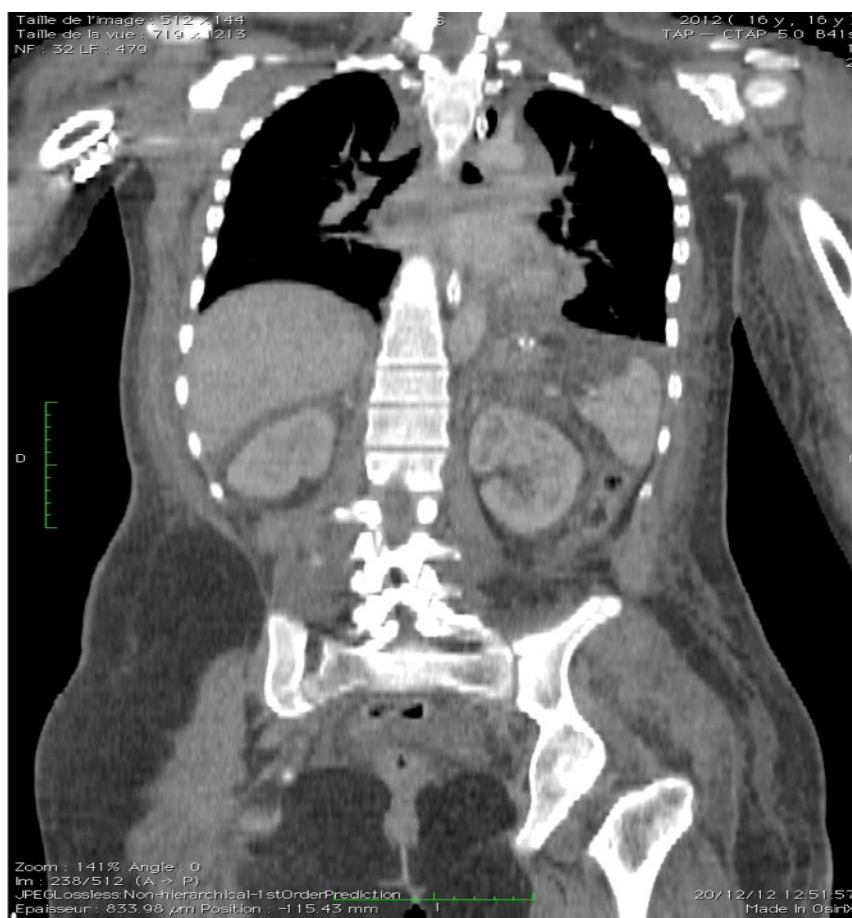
Thoracic CT scan, performed after intubation and chemotherapy treatment
